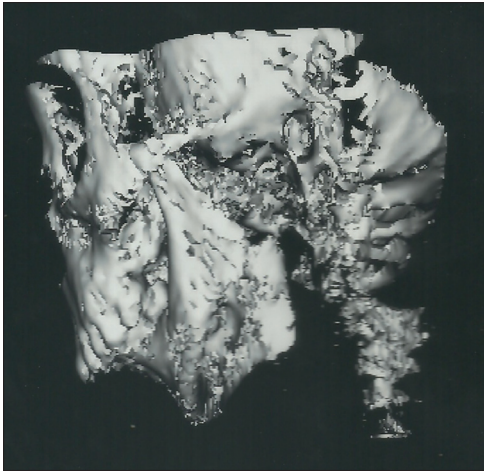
Denta scan (CBCT) of the patient showing absence of condylar process
